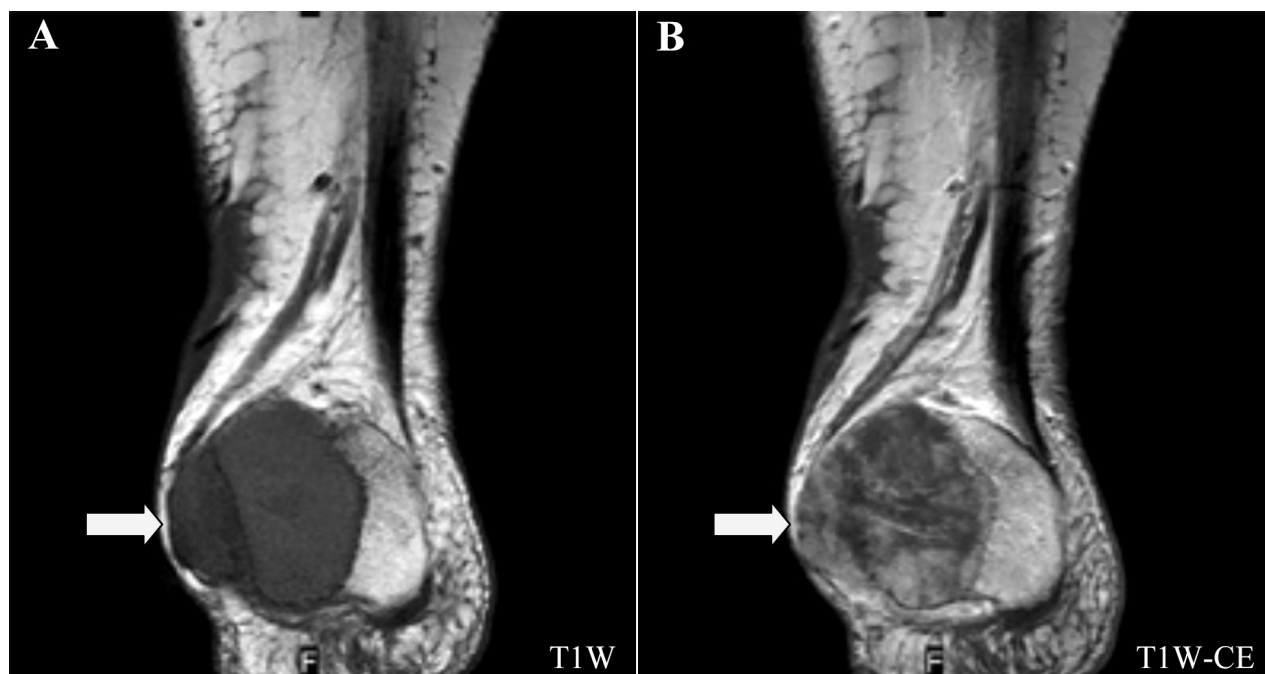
MRI showing a four cm tumor with heterogeneous enhancement located on the right calcaneus; A) T1-weighted image (T1W). B) Contrast-enhanced T1-weighted image (T1W-CE).
